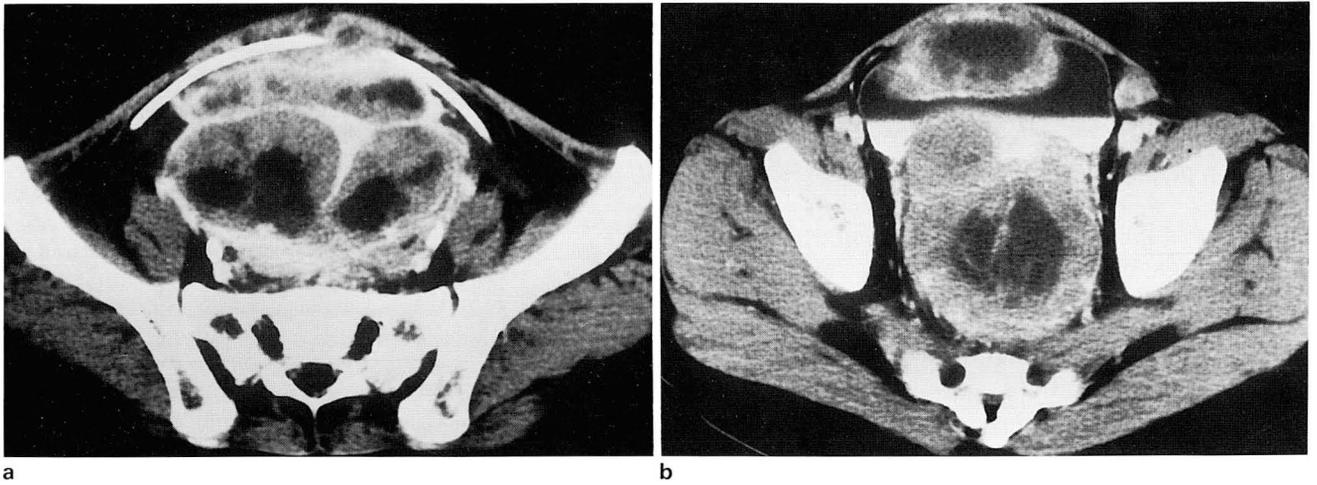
Postcontrast CT scans at different levels of the pelvis 3 years and 8 months after the VP shunt. A large, heterogeneously enhancing, mixed-density tumor surrounds distal portion of the VP shunt catheter(a). Extrinsic compression or invasion anteriorly and posteriorly on contrast-filled bladder is also demonstrated(b).
